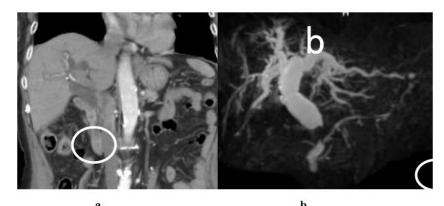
Contrast enhanced computed tomography (a) and Magnetic Resonance Cholangiopancreatography (b) reveal marked dilatation in the intrahepatic bile duct and upper and middle extrahepatic bile duct, with a narrowed lower extrahepatic bile duct
